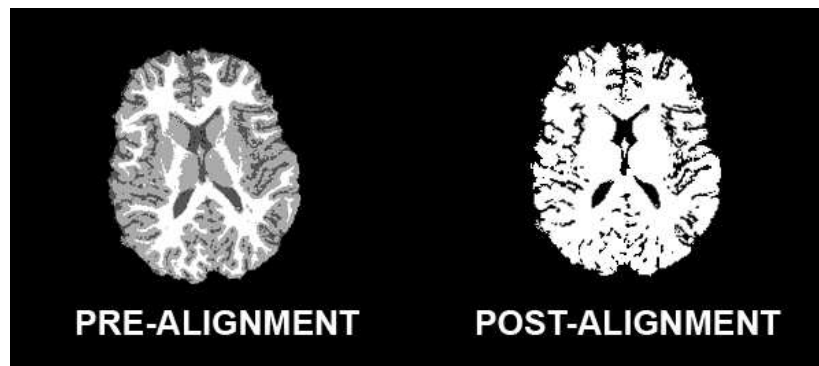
Pre- and post-alignment views of a MRI brain slice. In a properly oriented scanner the changes are minimal to the volume. Uncorrected, these small changes introduce errors when comparing multiple volumes.
